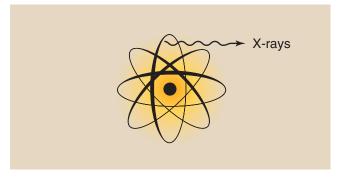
X-rays are produced outside the nucleus of excited atoms.
